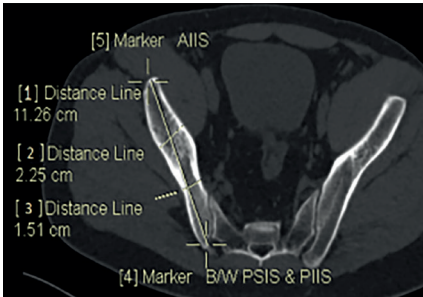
Path B [Point between PSIS and PIIS to AIIS]. Double oblique reformatted CT image showing Path B trajectory; where [1] represents its length, while [2] and [3] represent width of its narrowest zones, [2] being anterior to [3].
